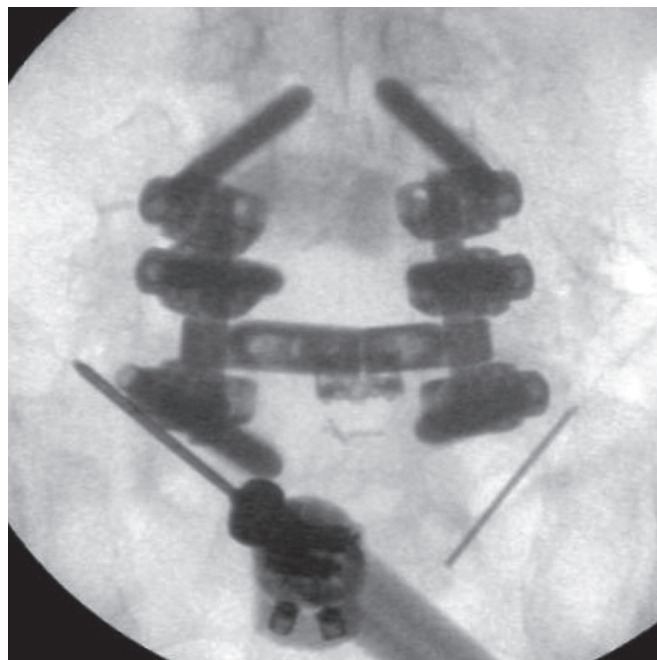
X-rays of lumbar fusion—anteroposterior view
